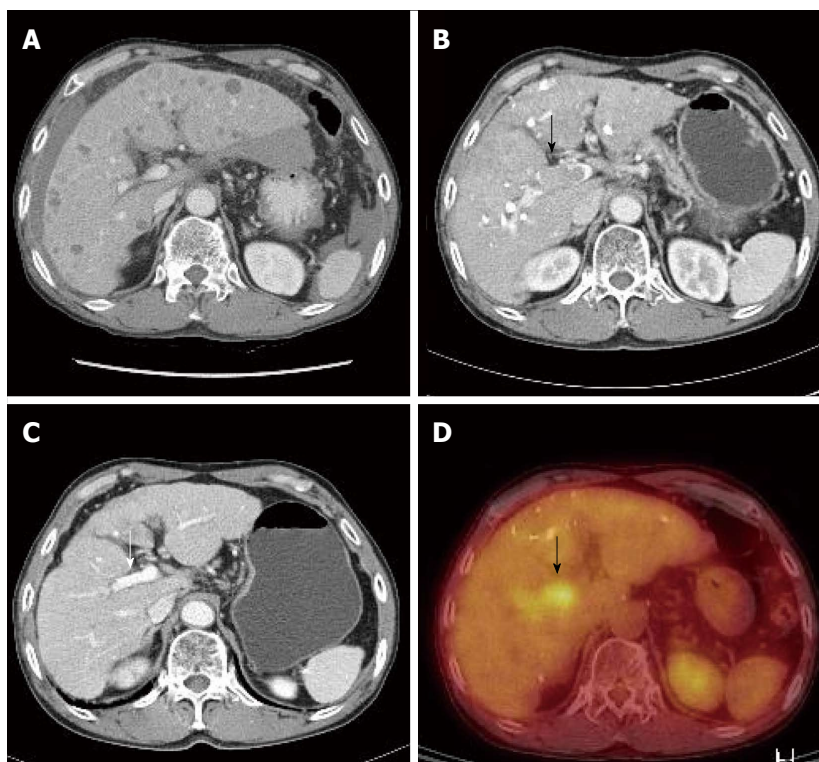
The diagnosis of portal vein tumor. A, B, D: Portal vein tumor (A), which was not evident at diagnosis, was detected by liver dynamic computed tomography (CT) (B, black arrow) and positron emission tomography-CT (D, black arrow) after four sessions of transarterial chemoembolization; C: Portal vein tumor improved after 3 mo of sorafenib (white arrow).
